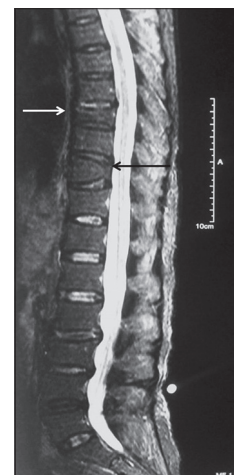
Sagittal T2 W MR image of spine shows moderate/grade 2 fracture in D10 and severe/grade 3 fracture in D8 (arrows) with maintained marrow signal intensity. There is no hyperintensity or bone marrow edema on T2 W image suggestive of chronic fractures
